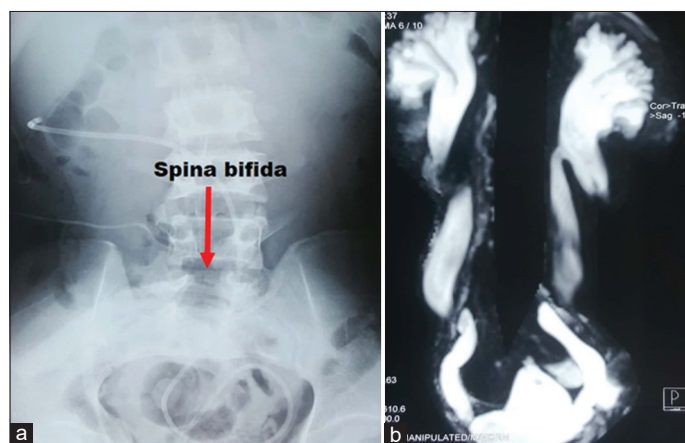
(a) Plain X-ray kidney, ureter, and bladder region shows L4-5 spina bifida. (b) Plain magnetic resonance urogram shows B/L hydronephroureterosis with irregular thickened bladder
